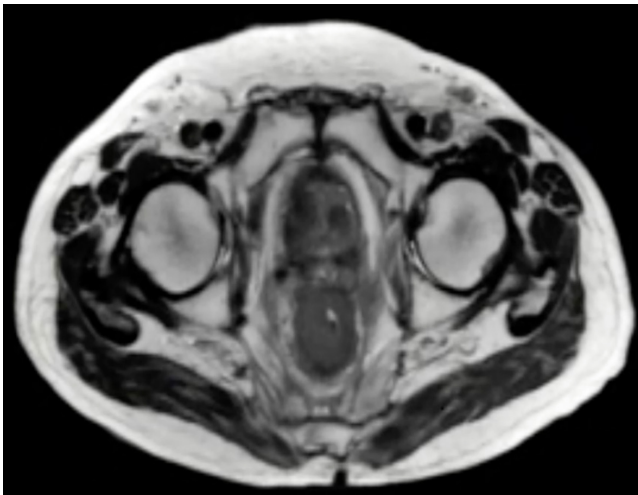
T2-weighted pelvic MRI showing concentric thickening of the rectal walls. Image property of the authors.
